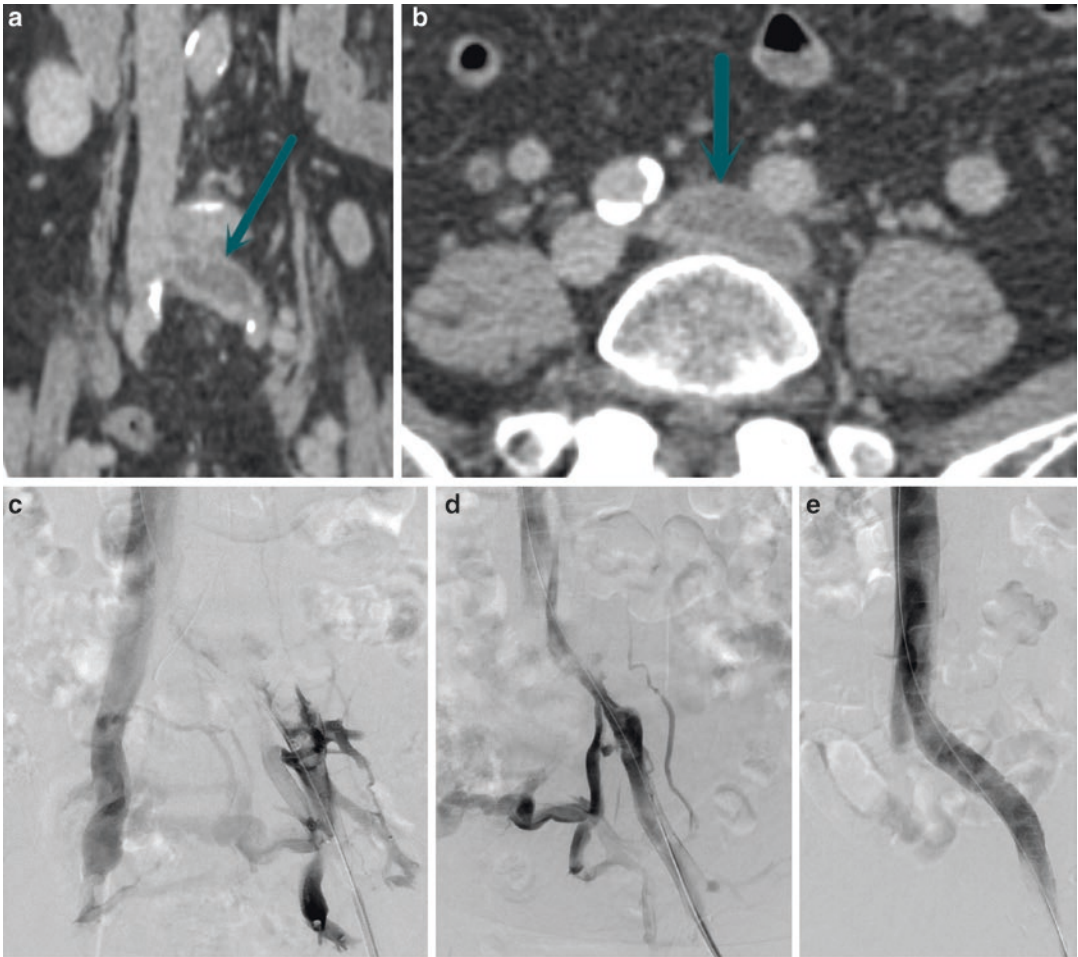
Seventy-three-year-old female presented with an acute onset of left lower extremity pain and swelling. CT scan of the abdomen and pelvis with intravenous contrast demonstrated thrombus within the left common iliac vein (a, b). The patient was referred for a catheter-directed venogram and treatment. Contrast venogram via the left common femoral vein demonstrated thrombus within the left common iliac vein (c). Single-session percutaneous
